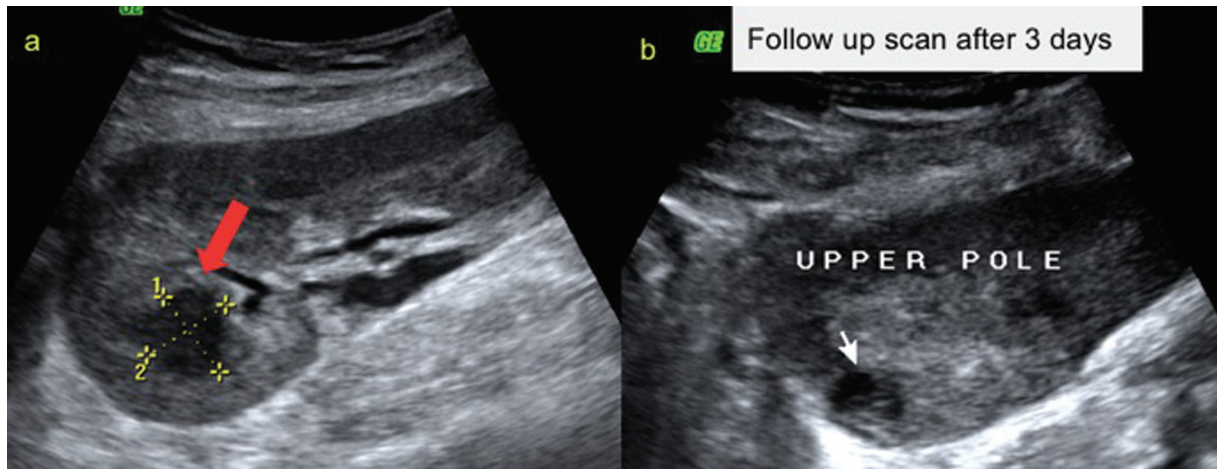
Ultrasound image (a) of a patient who presented with fever shows a hypoechoic lesion with irregular margins, which may represent an abscess (red arrow). Antibiotics were started and repeat ultrasound (b) after 3 days showed a decrease in the abscess size.
